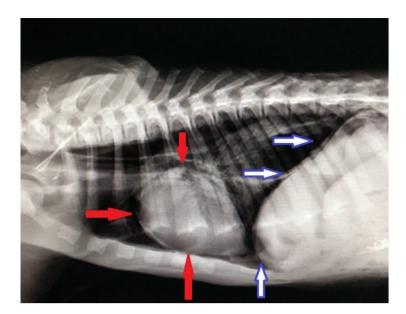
Postoperative radiographic findings; image of the heart (red arrows) and the diaphragm line (blue-white arrows).
